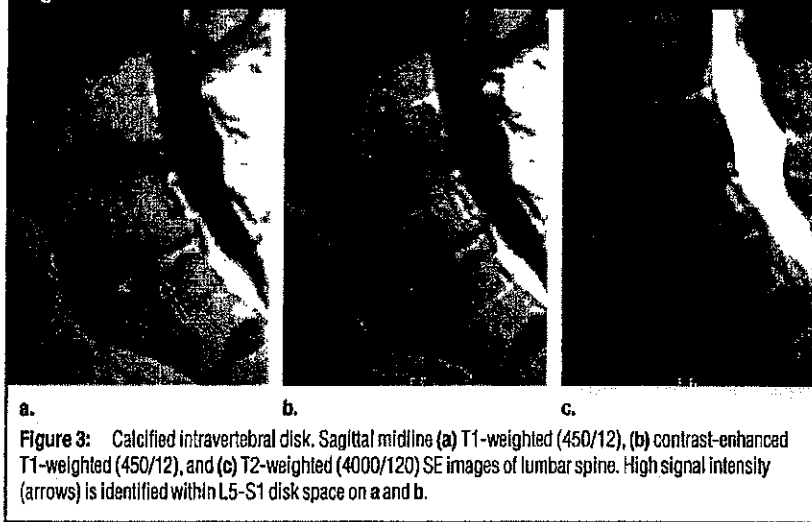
Calcified intravertebral disk. Sagittal midline (a) T1-weighted (450/12), (b) contrast-enhanced T1-weighted (450/12), and (c) T2-weighted (4000/120) SE images of lumbar spine. High signal intensity (arrows) is identified within L5-S1 disk space on a and b.
